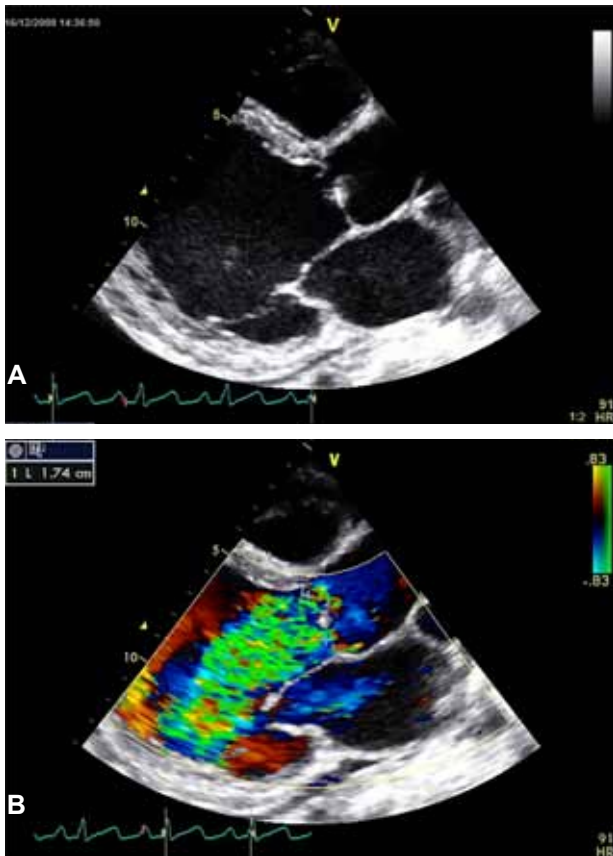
A. 2D-echocardiogram imaging from the parasternal long-axis view, showing left coronary cusp rupture of the aortic valve in the left ventricle during diastole, vegetation on the non-coronary cusp, left ventricular dilatation, and mild pericardial effusion. B. Color-Doppler showing severe aortic regurgitation (green color) with *vena contracta* 1.74 cm.
